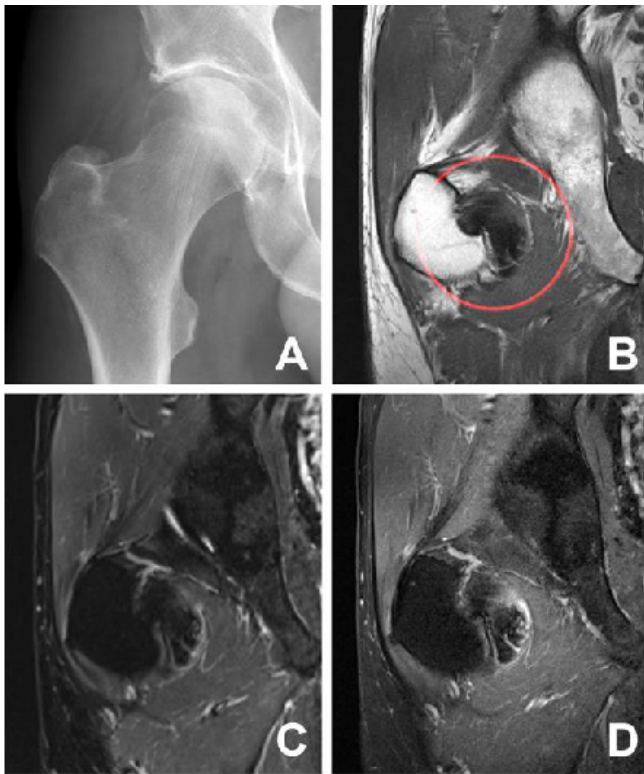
52-year-old male patient with biopsy-proven focal TSGCT medial to the greater trochanter. Anteroposterior x-ray (A) shows mild contour irregularity of the medial aspect of the lesser trochanter. Coronal T1 (B), STIR (C) and post-contrast T1 fat sat (D) reveal a lobulated hypointense mass with heterogeneous peripheral enhancement and erosion of the adjacent lesser trochanter. The hypointense signal is related to hemosiderin deposition within the mass.
